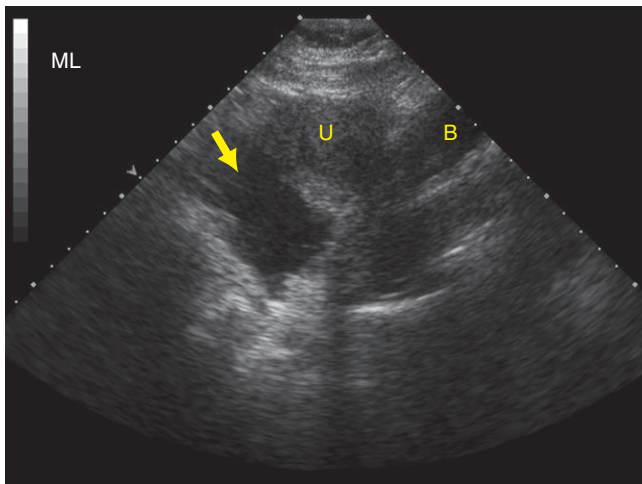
Ultrasound of the pelvis is obtained demonstrating free fluid (U=uterus and B=bladder).
